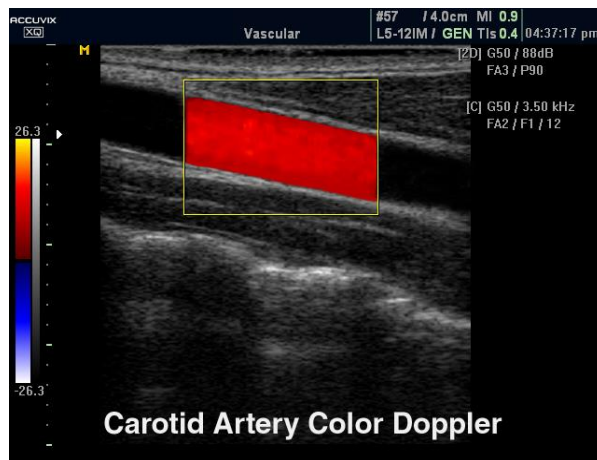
Color Flow Doppler of Carotid Artery. Red color shows the relative direction of blood flow to the transducer position (flowing toward the transducer) [29].
